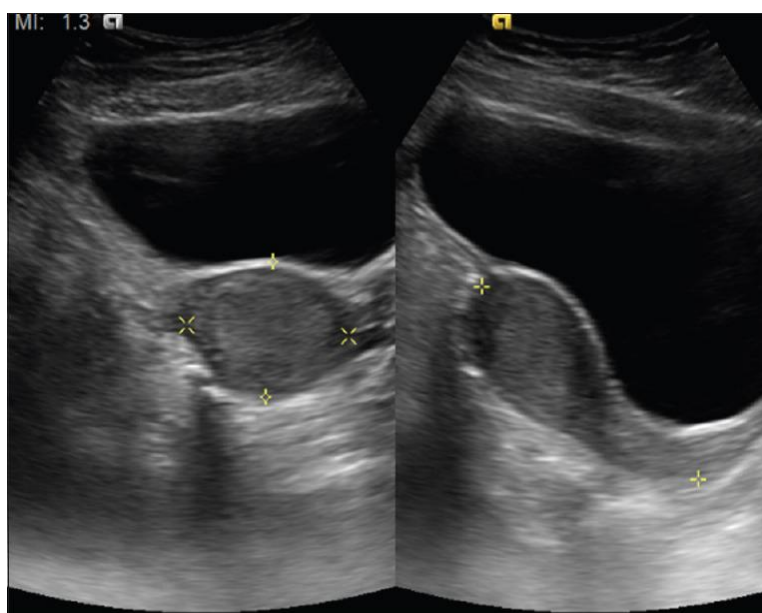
1 Assessment of adnexal masses using ultrasound
